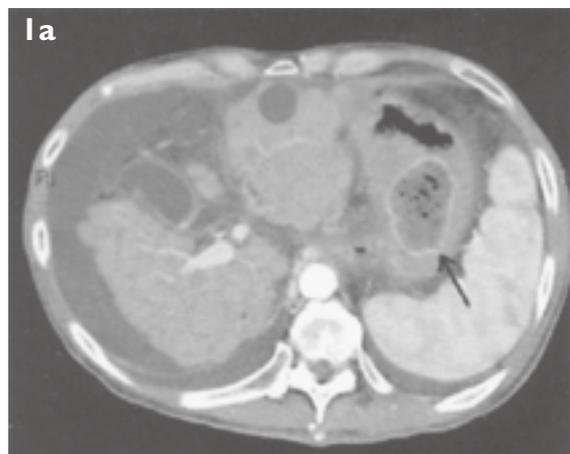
Enhanced axial CT images of the upper abdomen taken during (a) arterial, (b) portal venous, and (c) delayed phases.
